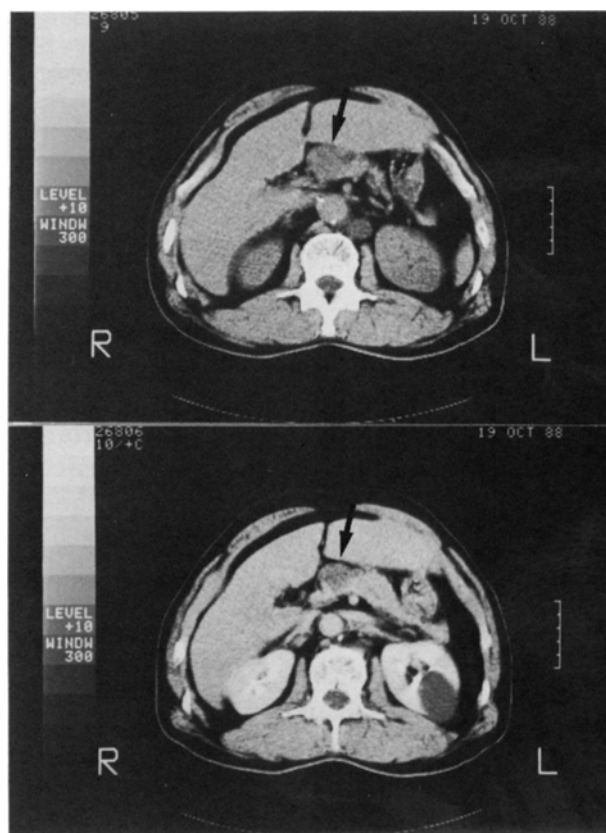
a: Plain CT scan of the abdomen showed a round low density area protruding from the surface of the pancreas (arrow).
